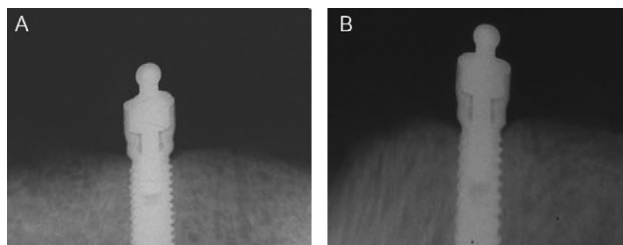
Periapical radiograph of the right (A) and left (B) implants with ball abutments after 7 years.
